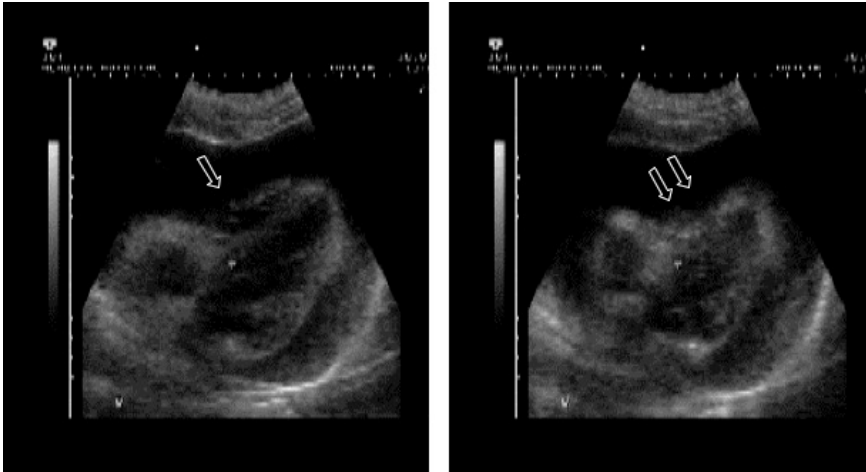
Cardiac ultrasound demonstrating large pericardial effusion and right ventricular collapse. Impaired filling of the right ventricle during diastole is visible (arrow) during inspiration. This even increases during expiration, when right ventricle almost collapses (2 arrows). (Courtesy Dr. Tom Heller, Munich)
